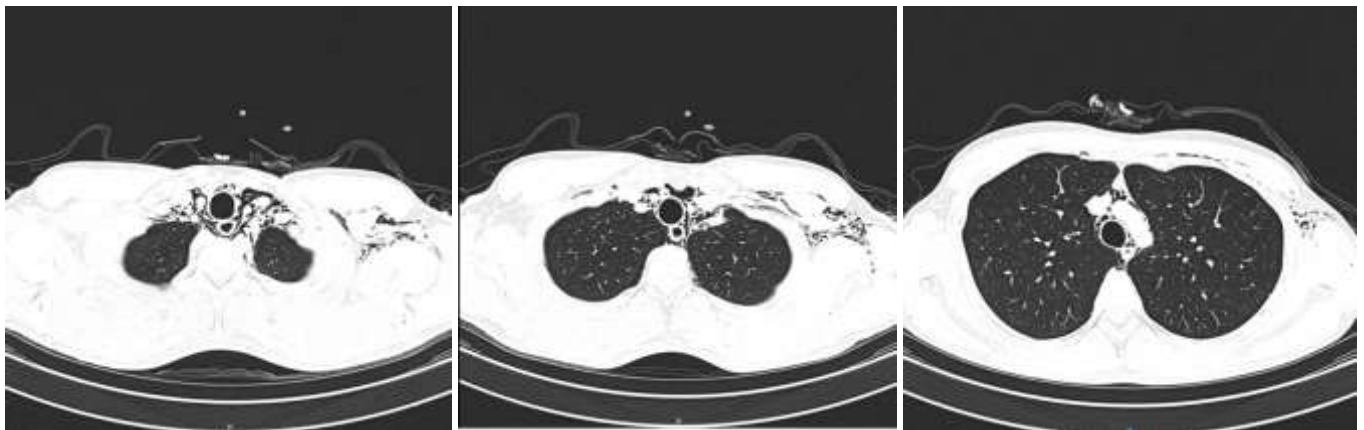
Chest CT. Chest CT scan reveals emphysema in both pectoral regions, predominantly on the left, extending towards the axillary region. Associated with this finding is the presence of gas in the mediastinum, distributed concentrically around the vascular structures, the trachea, and the esophagus. No parenchymal lesions are observed
